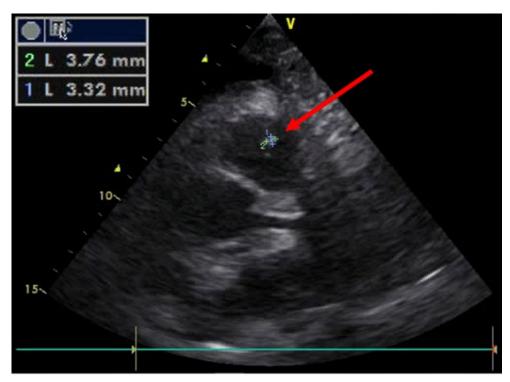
Transthoracic echocardiography basal short axis view showing reduction in the vegetation size (3.32 x 3.76 mm) attached to the pulmonary valve (red arrow). The yellow V signals the transducer marker.
